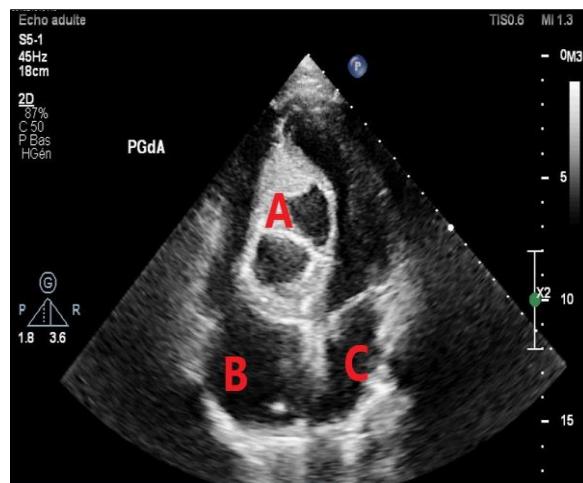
Transthoracic Doppler echocardiography in apical four-chamber view (A = abscess cavity within the interventricular septum; B = left atrium; C = right atrium)
